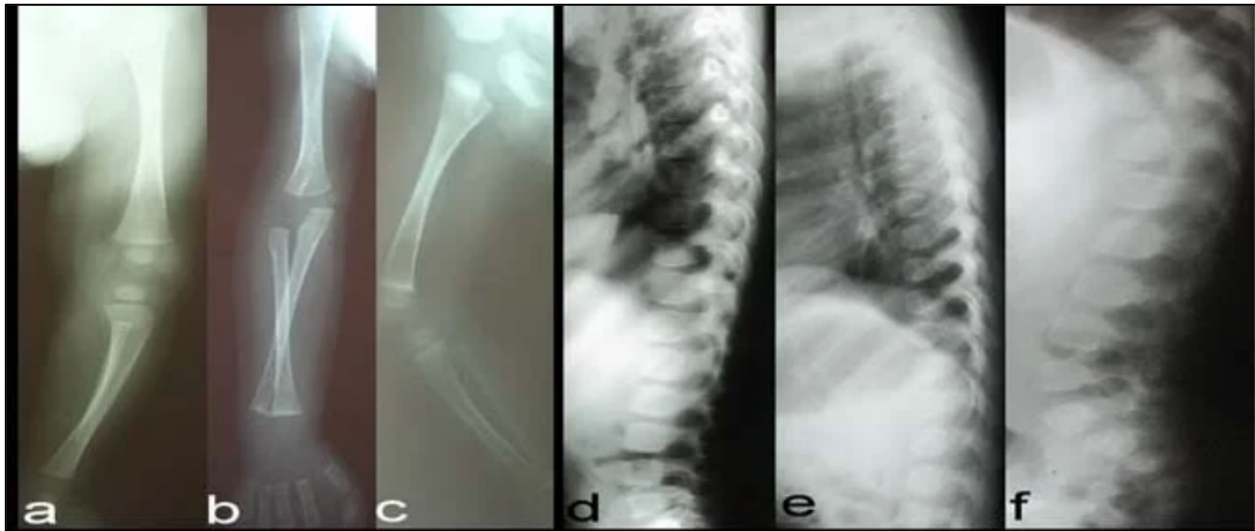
Interpretation of osteopenia in long bones using radiograph; patient 1 at the age of 2 months (a), patient at the age of 4 months (b), patient at the age of 8 months (c). Mild platyspondyly in a patient at the age of 2 months (d), patient having round vertebral bodies at the age of 4 months I, patient having mild platyspondyly at the age of 8 months (f). (11)
